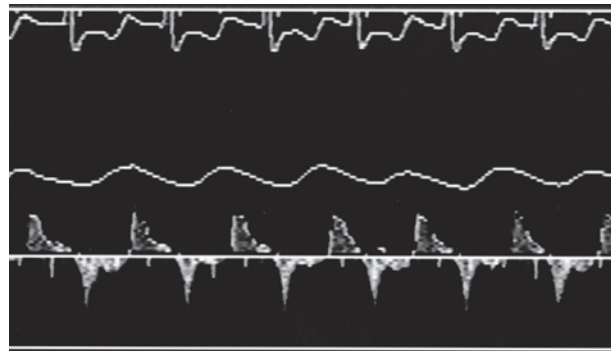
Intracoronary Doppler flow pattern in the distal first septal branch following alcohol-induced septal ablation for therapy-resistant hypertrophic obstructive cardiomyopathy. Angiography demonstrated a typical no-reflow pattern while intracoronary Doppler shows systolic retrograde flow followed by an early deceleration of diastolic flow.
